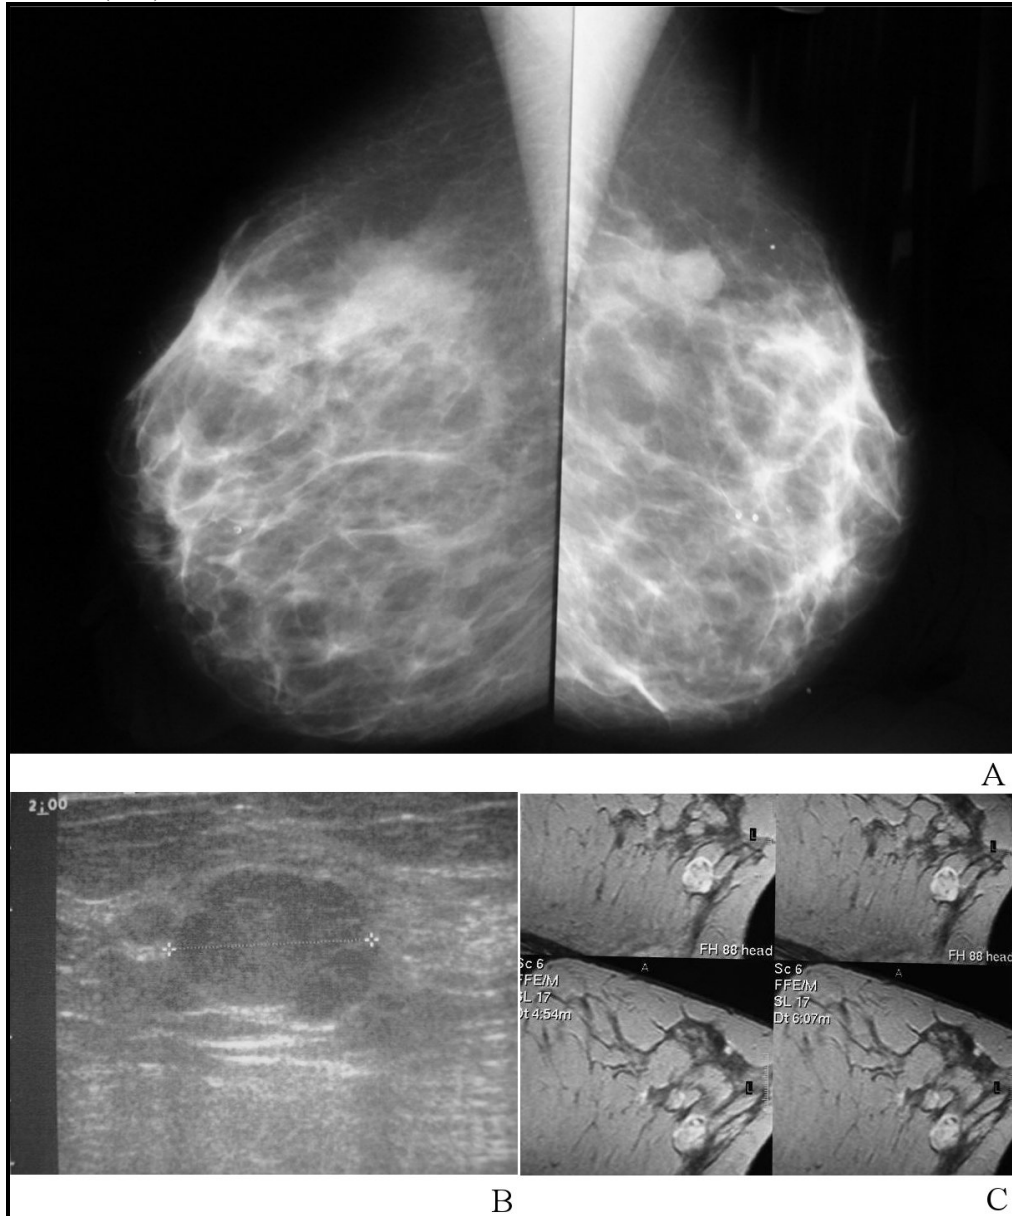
(a) 35 years old woman with history of fibroadenoma in the upper external quadrant of the left breast. Mammography shows nodular opacity with affected contours in the upper external quadrant of the left breast. (b) Gray-scale sonogram reveals hypoechoic solid lesion exhibiting one microlobulation. (c) T1-weighted post contrast axial MR images show non enhanced internal septation.
